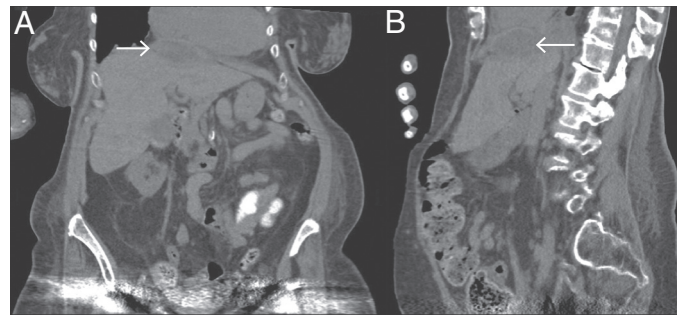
(A) Coronal and (B) sagittal abdominal computed tomography (CT) showing subdiaphragmatic collection (arrows).
